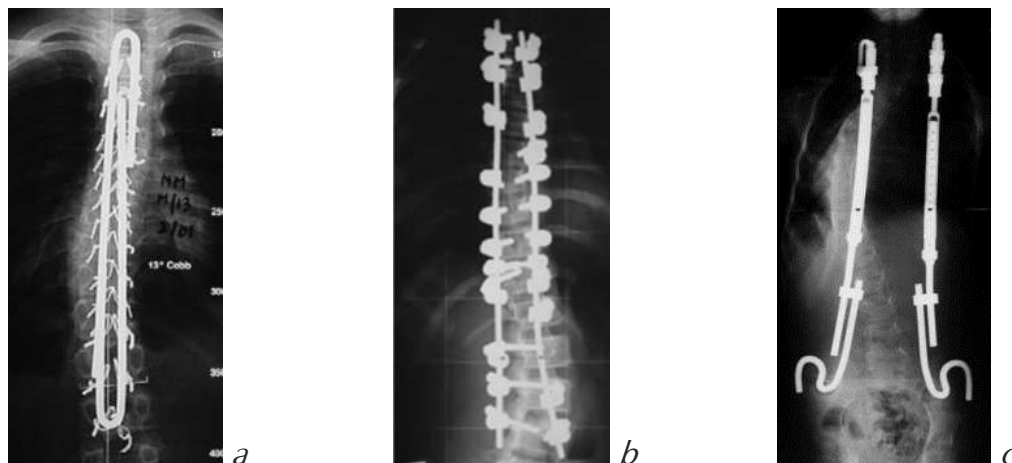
Radiographs of novel approaches in non-fusion surgery
